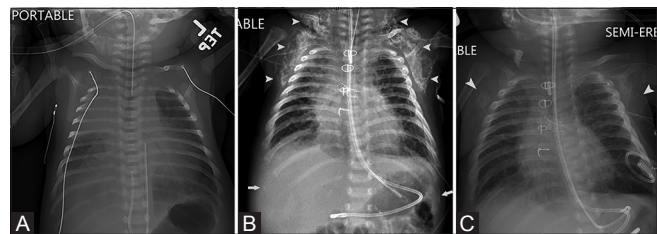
(A-C): Ex full term infant with hypoplastic left heart syndrome who underwent a stage I Norwood procedure and Sano right ventricle to pulmonary artery shunt at 1 week of age followed a little over a week later by acute decompensation requiring pressor support, large right pneumothorax and thoracotomy with chest exploration and large right hemothorax evacuation. Chest radiograph at 4 days old (A) demonstrates absence of soft tissue calcifications. Chest radiograph at 10 weeks (B) demonstrates significant bilateral soft tissue calcifications in the bilateral axillae, peri-scapular, peri-clavicular regions (white arrowheads) as well as the bilateral upper quadrants of the abdomen as indicated by white arrows. Chest radiograph at 3 months (C) demonstrates near complete interval resolution of soft tissue calcifications (white arrowheads)
